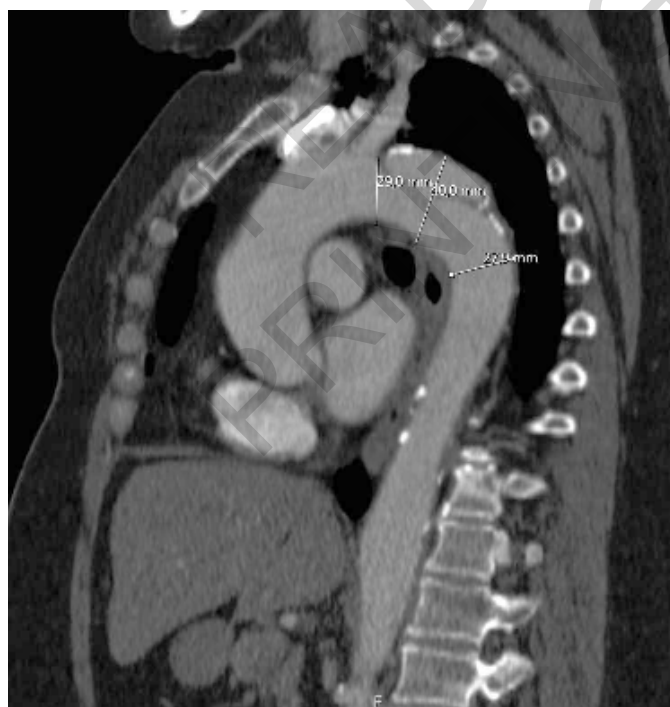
CT scan showing the acute type B aortic dissection
